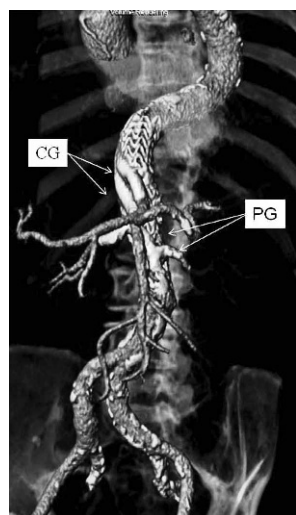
♦ Postoperative CT reconstruction after endovascular repair with 2 renal periscopes (PG) and 2 visceral chimneys (CG) in a patient with a Crawford type IV TAAA (case 4).
